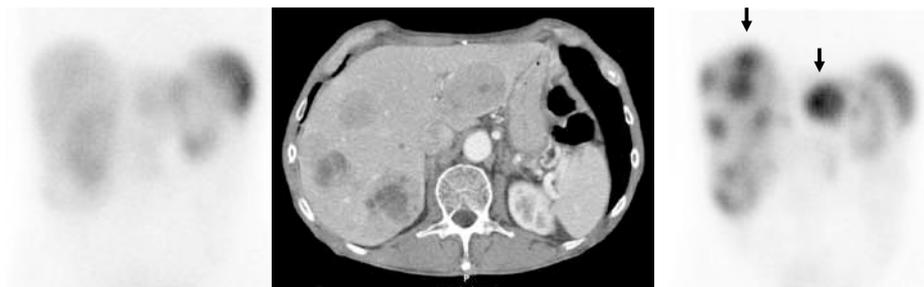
Difference in tumour uptake between [^{111}In -DTPA 0]octreotide and [^{177}Lu -DOTA 0 ,Tyr 3]octreotate in a patient with a midgut carcinoid with liver metastases. *Left panel:* Scintigraphy 24 hours after injection of 200 MBq [^{111}In -DTPA 0]octreotide did not clearly demonstrate pathological uptake despite the quite large liver metastases visible on CT (*middle panel*). On SPECT images (not shown) uptake in liver metastases was equal to normal liver uptake (grade 2 uptake, see legend to Figure 4). *Right panel:* On scintigraphy 24 hours after injection of 7.4 GBq [^{177}Lu -DOTA 0 ,Tyr 3]octreotate liver metastases were clearly visualised (arrows).
